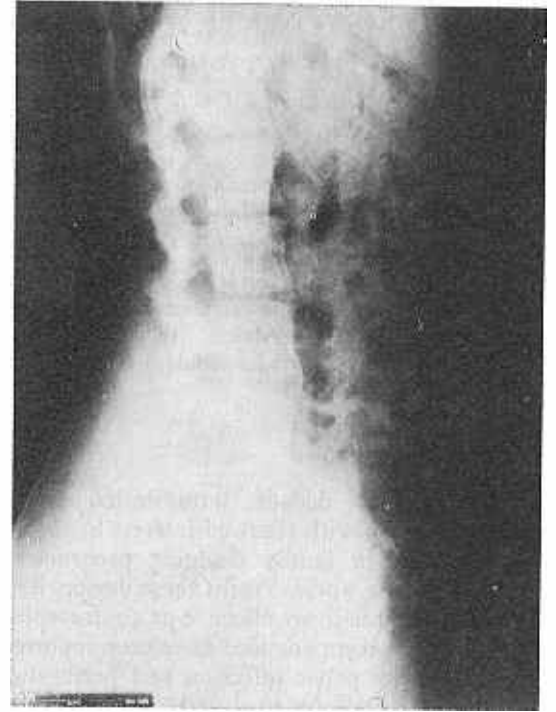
Lateral X-ray film of case 2 showing the high extra-uterine position of the device, close to posterior abdominal wall.
